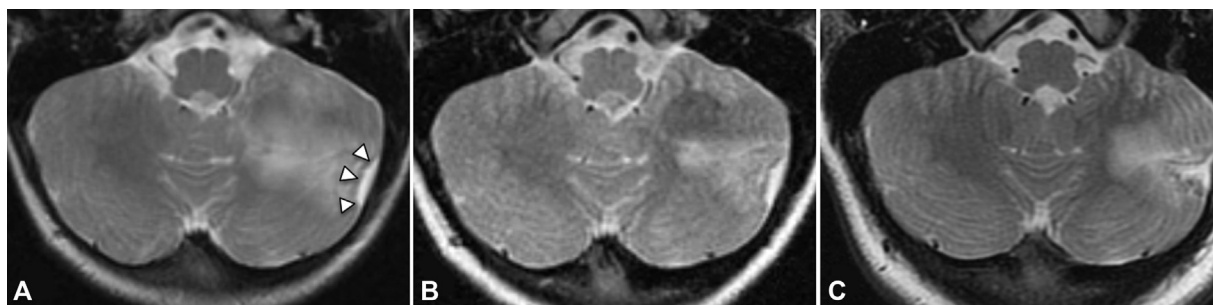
Initial magnetic resonance imaging (MRI) (A) and follow-up MRIs performed 3 years (B) and 7 years later (C) for a left cerebellar tuber. (A) The tuber shows hyperintensity on T2-weighted image (T2WI). A retraction change is also present (arrowheads). The hyperintense area decreases 3 years later (B) and increases again 7 years later (C). The retraction change, on the other hand, keeps progressing.
